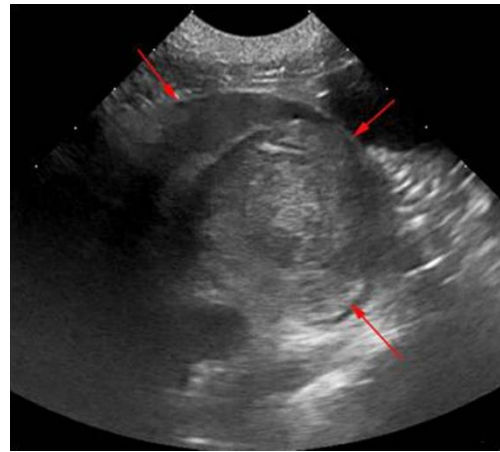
Ultrasonographic image of the right hemithorax showing the presence of a heterogeneous round mass surrounded by fluid.
